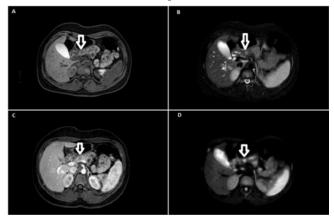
Contrast-enhanced MR imaging: centimetric focal pancreatic area with hypointensity in T1- weighted sequences (A), hyperintensity in T2-weighted sequences (B), hypoenhancement in arterial phase (C) and restrictive pattern in DWI sequences (D)(Arrows).
